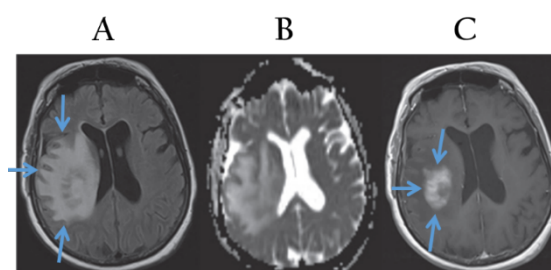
MRI scan from a patient with PCNSL. (A) Lesion is located in the right temporal lobe indicated by arrows. (B) The lesion displays reduced diffusion coefficient compared to surrounding areas. (C) Tumor with intense contrast enhancement in a gadolinium MRI image. From Korfel A. & Schlegel U. Nat. Rev. Neurol. 2013.
